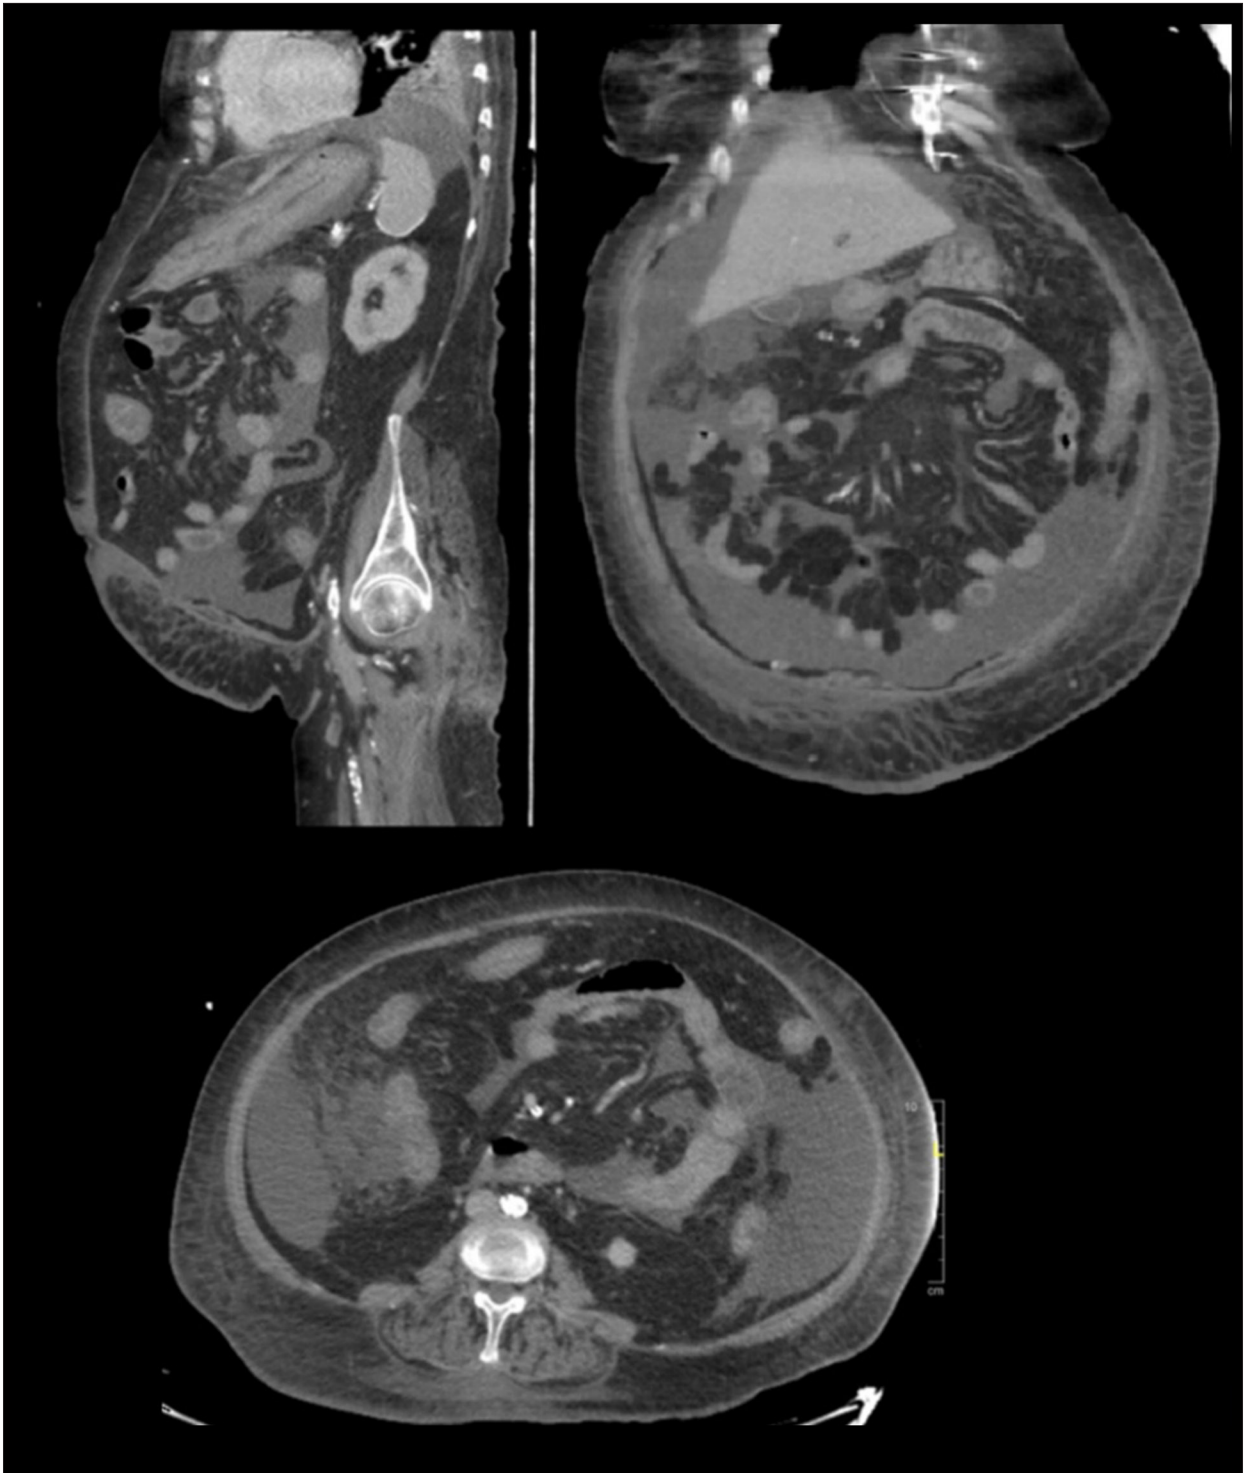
Abdominal and pelvis computed tomography scans showing circumferential wall thickening of the colon and rectum, prominent in the left transverse colon, and abdominopelvic free fluid with no free air.
